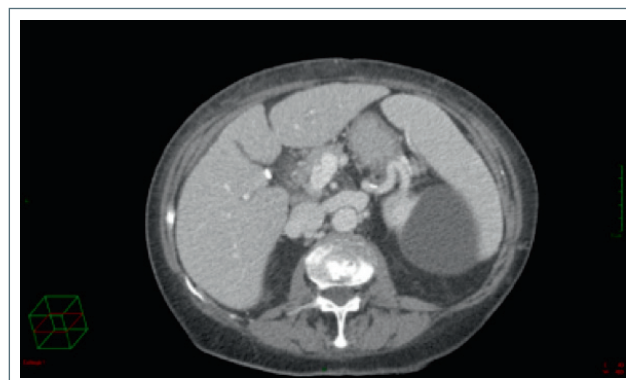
Abdominal CT scan – venous phase (first admission): no pancreatic lesions were observed.
